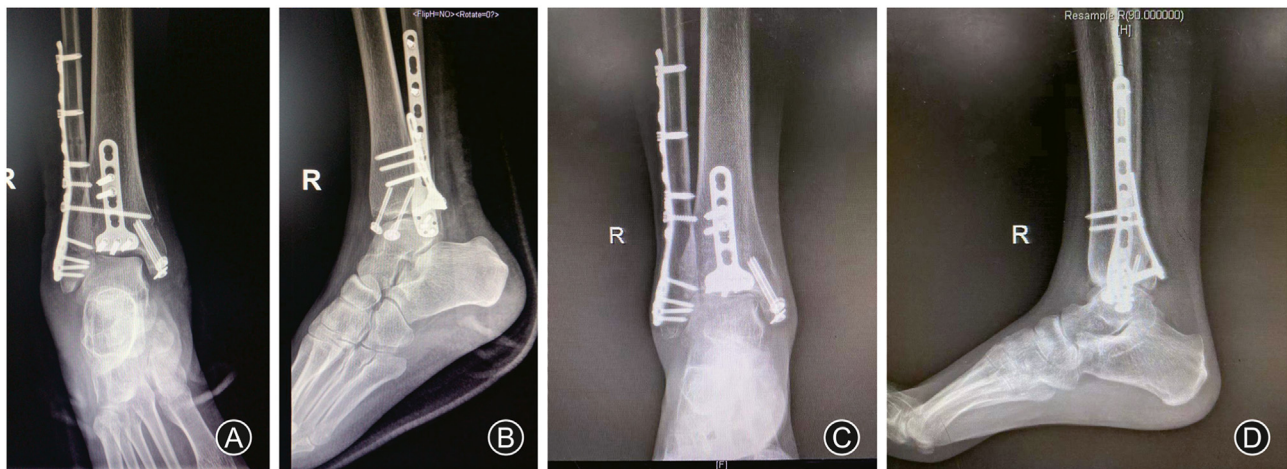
Postoperative imaging reexamination: postoperative (A) anteroposterior and (B) lateral radiographs of the ankle joint; (C) anteroposterior and (D) lateral radiographs of the ankle joint at the 1 year postoperatively.
